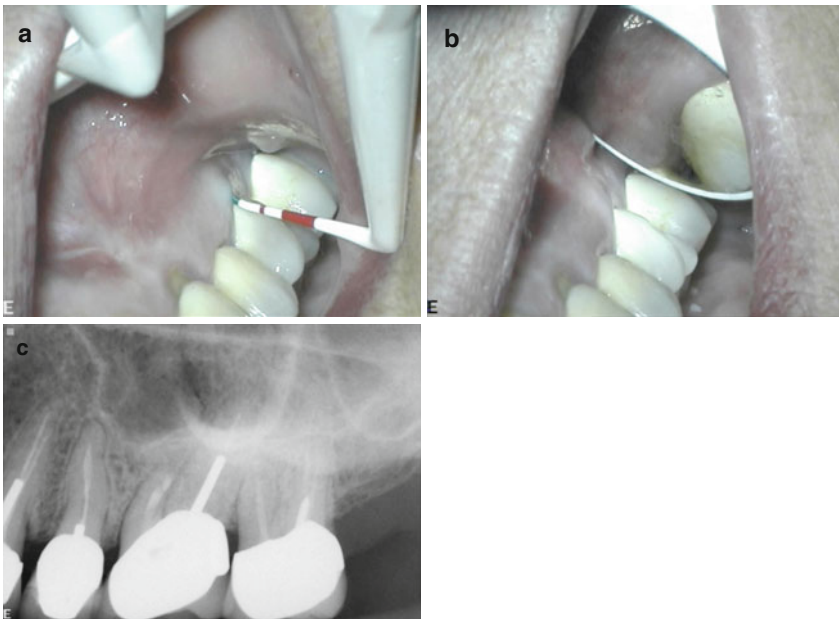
Continuation of case presented in Figs. 6.1 and 6.2: clinical soft tissue healing one year postoperative (a, b). One-year postoperative recall radiograph (c)
